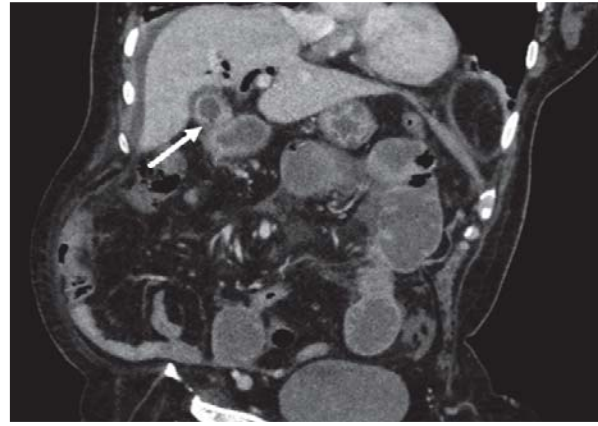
Coronal CT scan demonstrating an apparent break between the gallbladder and the lumen of the duodenum (white arrow).
